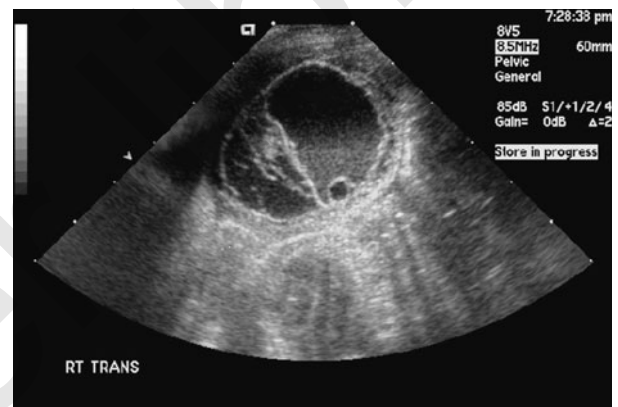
Transabdominal ultrasound of a complex ovarian cyst, 2.5 × 3.5 cm. Features include a relatively thick cyst wall, fluid/debris level, and multiple septations. This ovary was found to be torsed and non-viable.
